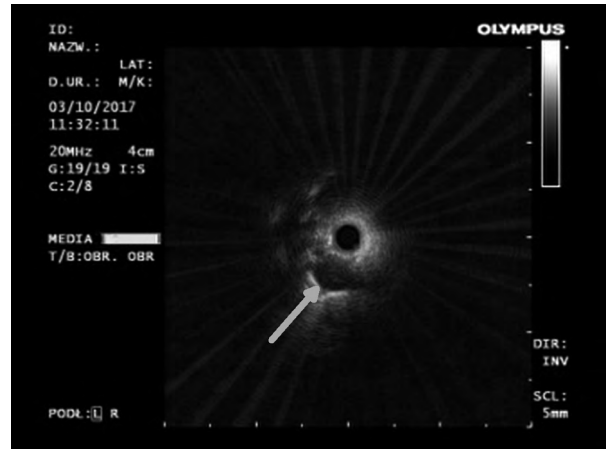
Ultrasound imaging of the subsegmental pulmonary artery (white arrow) obtained with radial endobronchial ultrasound mini-probe (rEBUS). Biopsy in this site would cause significant bleeding. With the consent of the Archives of Endoscopy Unit of Pulmonary Hospital, Zakopane
